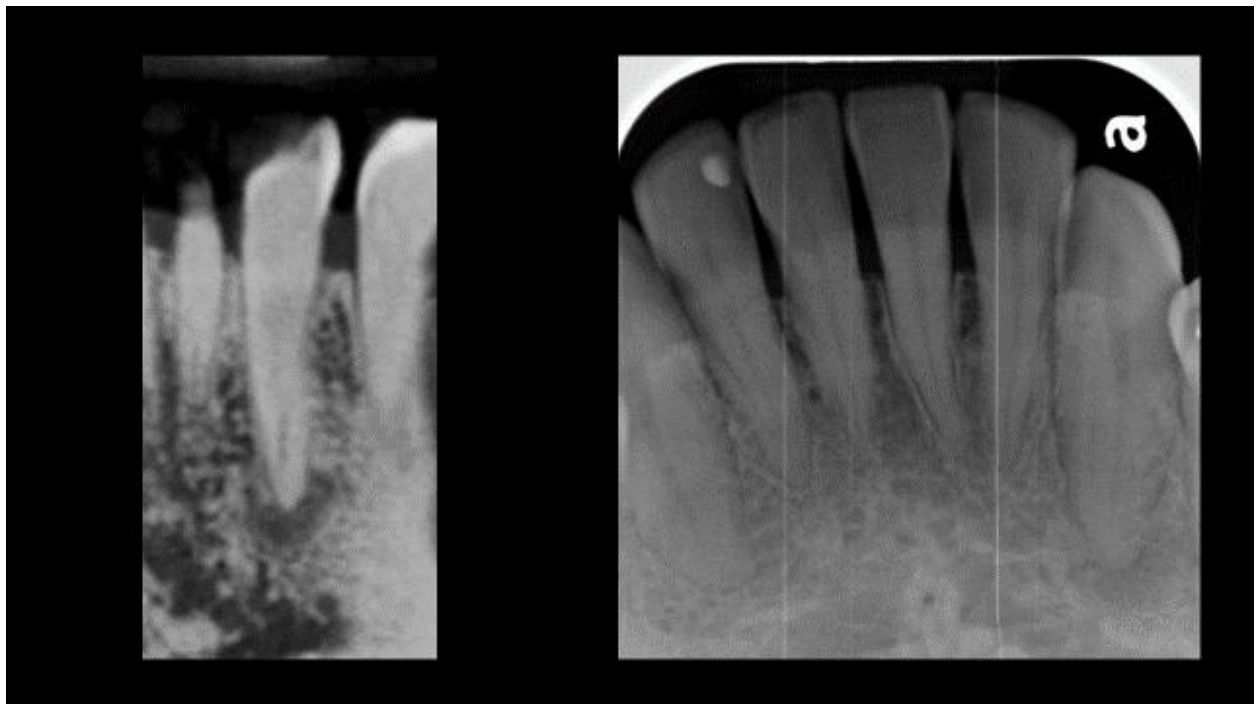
Periapical Cemento Osseous Dysplasia CBCT (left) not visible on PA (right)
